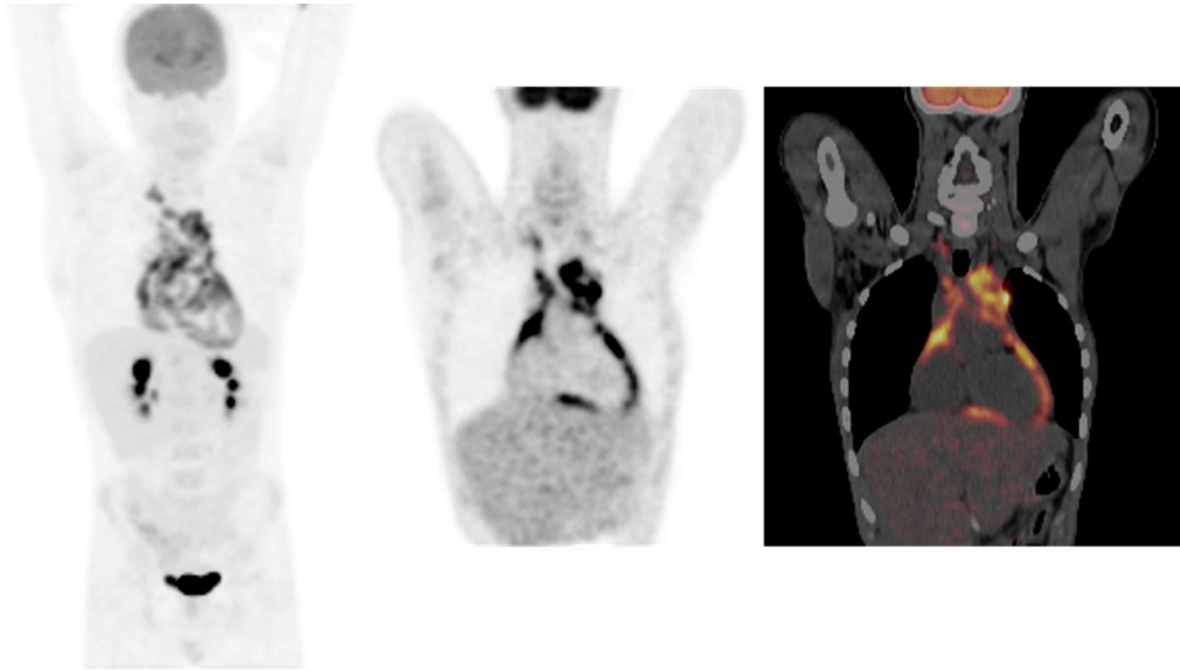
Tuberculous pericarditis. A 16-year-old male with an 11-year history of HIV infection with a sudden onset of chest pain. FDG PET/CT was obtained as part of his work-up. Images show intense FDG uptake in the pericardium and multiple mediastinal and right supraclavicular lymph nodes. The supraclavicular lymph node was biopsied and confirmed tuberculosis. Intense FDG uptake in the pericardium with associated mediastinal and/or supraclavicular lymphadenopathy are highly suggestive of tuberculosis. The involved lymph node can be biopsied for definitive diagnosis.
